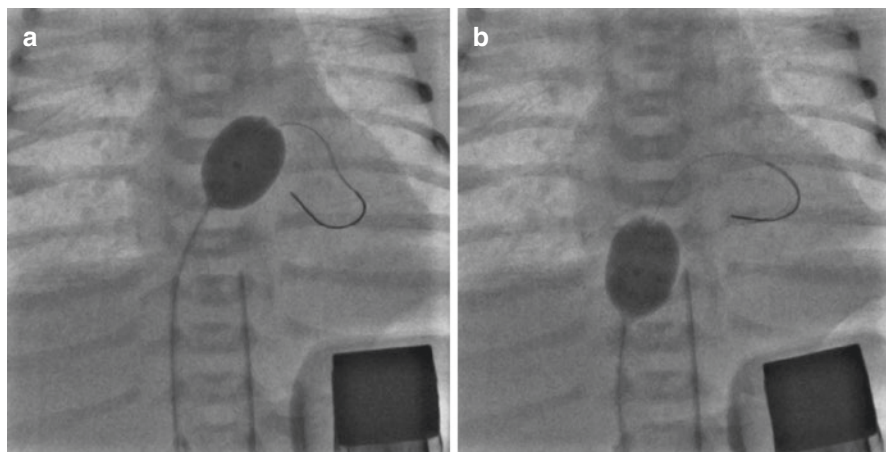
Balloon atrial septostomy under transthoracic echocardiography and fluoroscopy. (a) A 6 Fr septostomy catheter (NuMED, Inc., Hopkinton, NY, USA) is advanced over a wire to the left atrium, where the balloon is fully inflated by diluted contrast. (b) The septostomy catheter is pulled through the atrial septum to the right atrium
